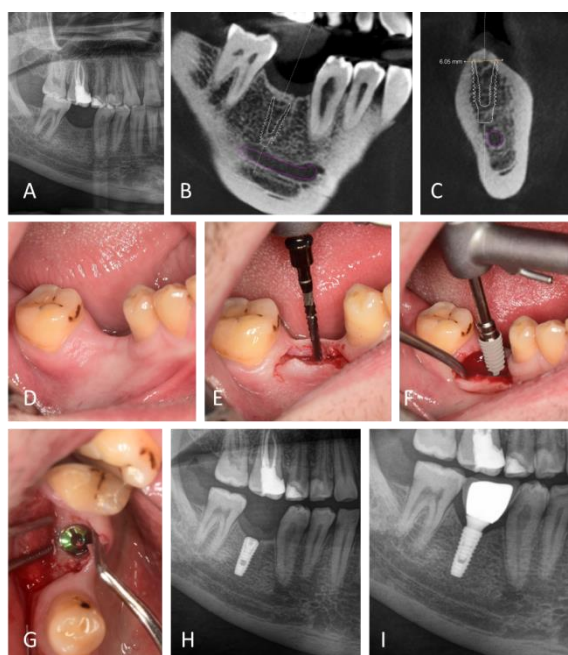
Clinical case of the standard implant placement protocol using the Dentium implant (SuperLine). A) Preoperative OPG image with a single-tooth mandibular edentation at the level of tooth 46; B, C) Images of longitudinal and sagittal CBCT with visible bone morphology and mandibular canal, consequent planning of implant dimensions, position and angulation; D) Image of edentulous mandibular alveolar ridge in the posterior region; E) Intraoperative image, after the mucoperiosteal flap displacement - marking the site of neoalveola creation and initiation of the drilling; F) The insertion of the implant at the level of tooth 46 (length – 12,0 mm, diameter – 4,0 mm); G) Intraoperative image after insertion of the implant and application of the covering screw; H) Postoperative OPG image, immediately
